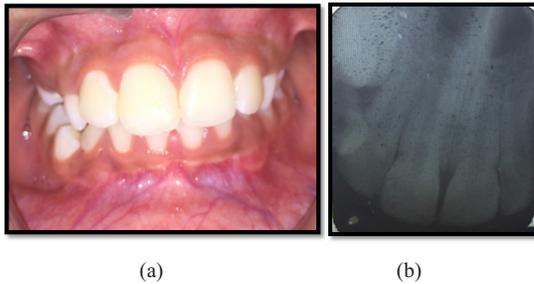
(A): Clinical view after 3-months follow-up. (b) Radiographic follow-up after 3- Months
